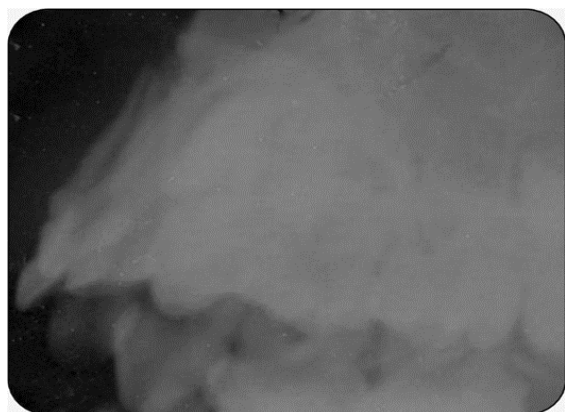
Lateral radiograph of the nose showing the labial root apex.
